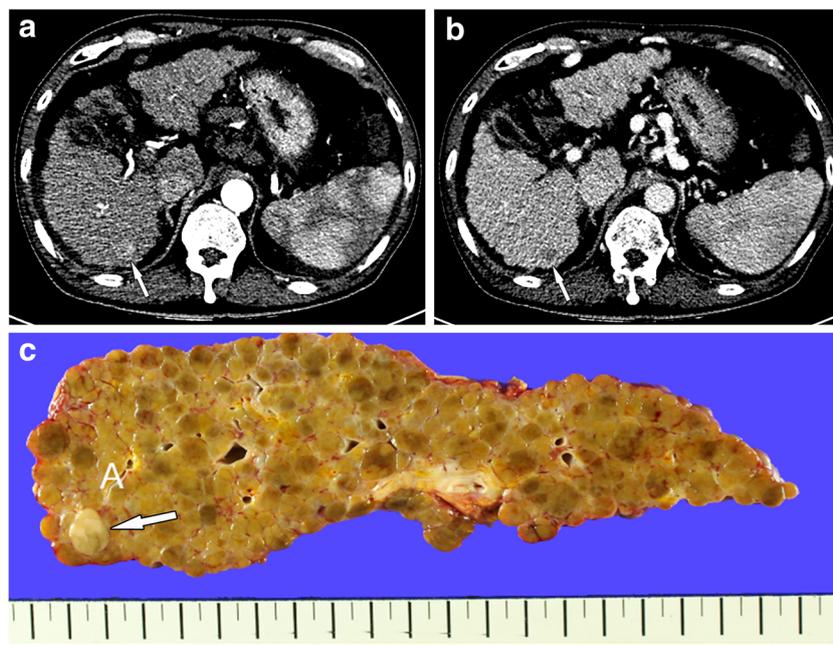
A 1.3-cm pathologically proven HCC lesion in a 61-year-old male. (a) An axial computed tomography (CT) image obtained in the late arterial phase shows a 1.3-cm enhancing nodule in segment VI of the liver (arrow). (b) CT image obtained in the portal venous phase shows washout of the arterial phase-enhancing nodule (arrow). On the basis of preoperative CT, this nodule was
